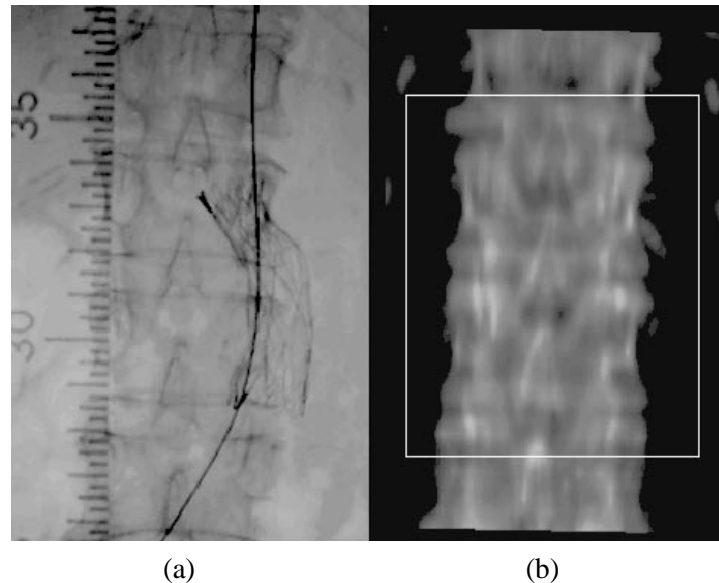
Fluoroscopy image (a) and digitally reconstructed radiograph (b) at registration.
